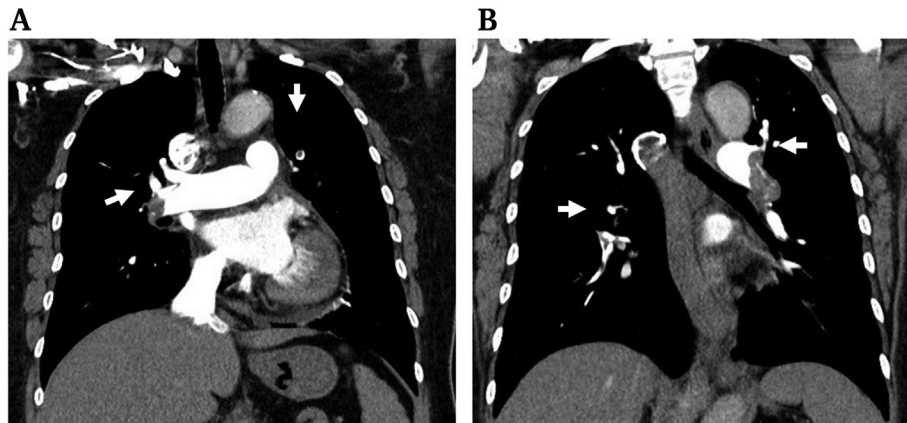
Computed tomography pulmonary angiography showing high burden thrombus (white arrow) in the right interlobar artery (A) and left main pulmonary artery (B).
